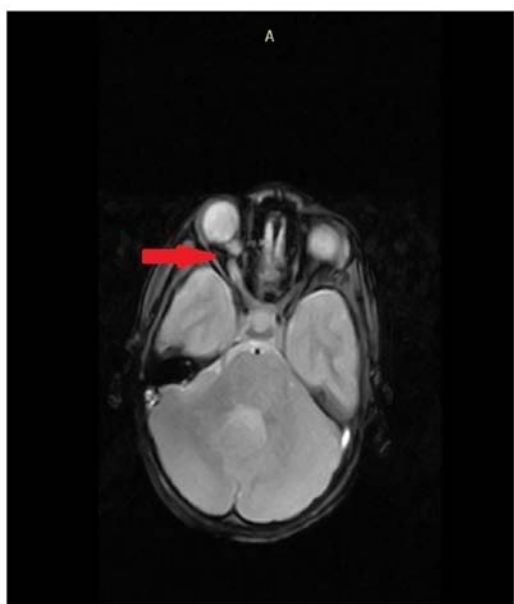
Anterior view of a MRI image in T-2 transversal section and the right optic nerve thick and sinuous of a patient, aged 8 years presenting to the Clinical Hospital for Children, Galati, Romania. A, anterior view.
